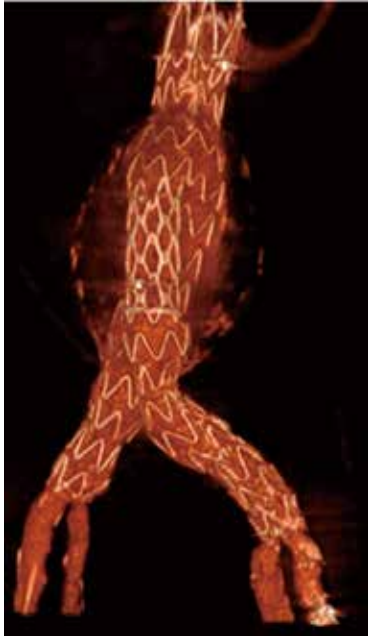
3D-computed tomography showing endovascular aneurysm repair for abdominal aortic aneurysm.
